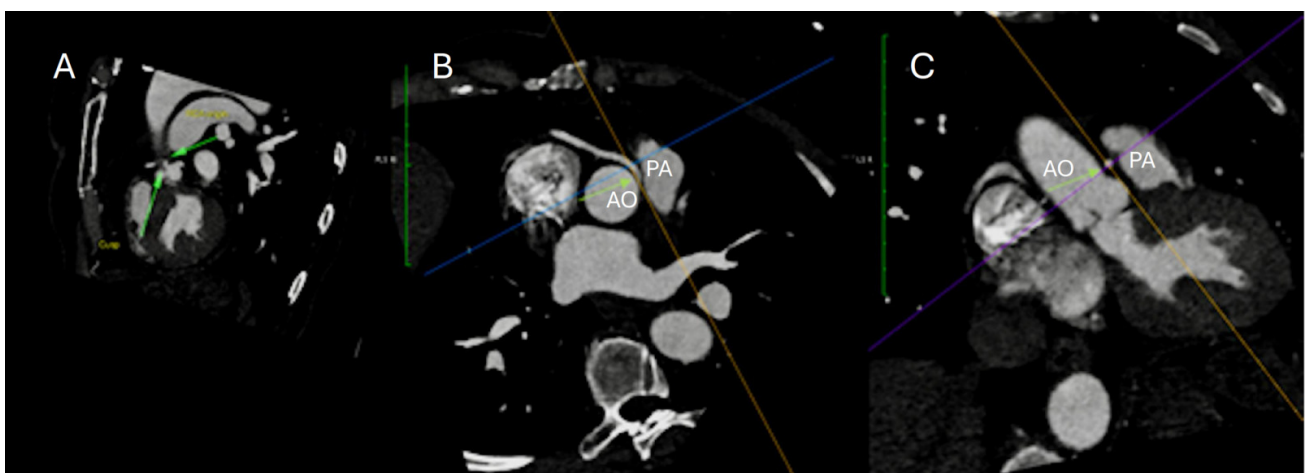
A: Axial contrast-enhanced CT image at the level of the great vessels demonstrating anomalous origin of the right coronary artery from the left coronary sinus (green arrows)
